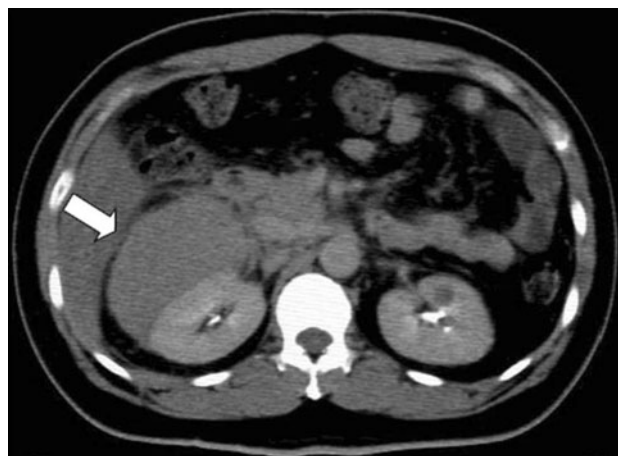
The abdominal CT scan at patient's 38-year-old revealed a subcapsular hematoma measuring 9.0 × 6.5 cm at the right kidney (arrow)
